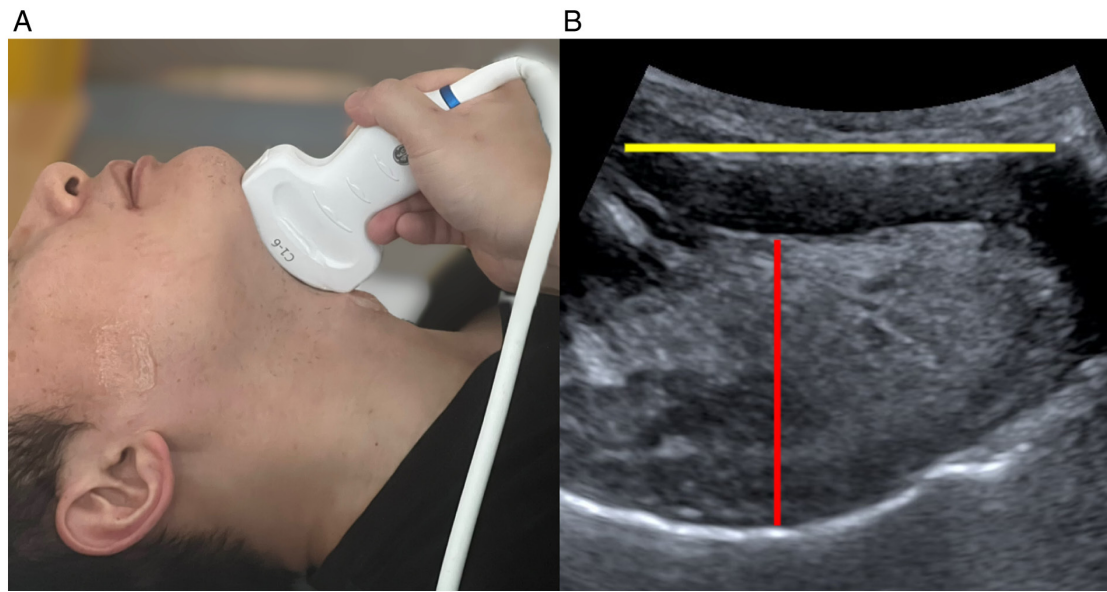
Ultrasound measurement of tongue thickness and hyoid-mental distance using a low-frequency curvilinear array probe. (A) Placement of the low-frequency curvilinear array probe in the submental region. (B) Measurement of tongue thickness (red line) and hyoid-mental distance (yellow line).
